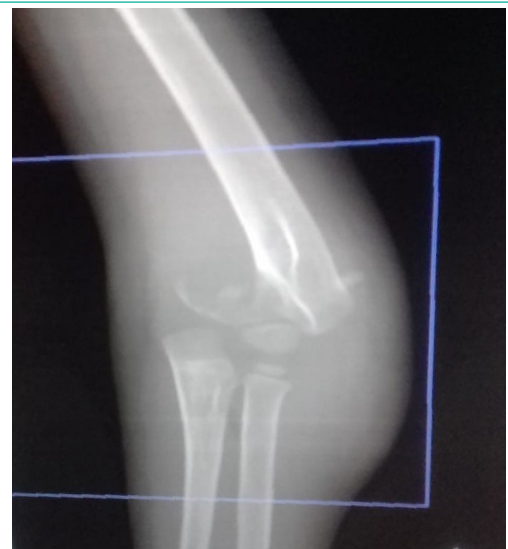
X-ray of the front of the elbow showing an anterior dislocation of the elbow with olecranon fracture.
